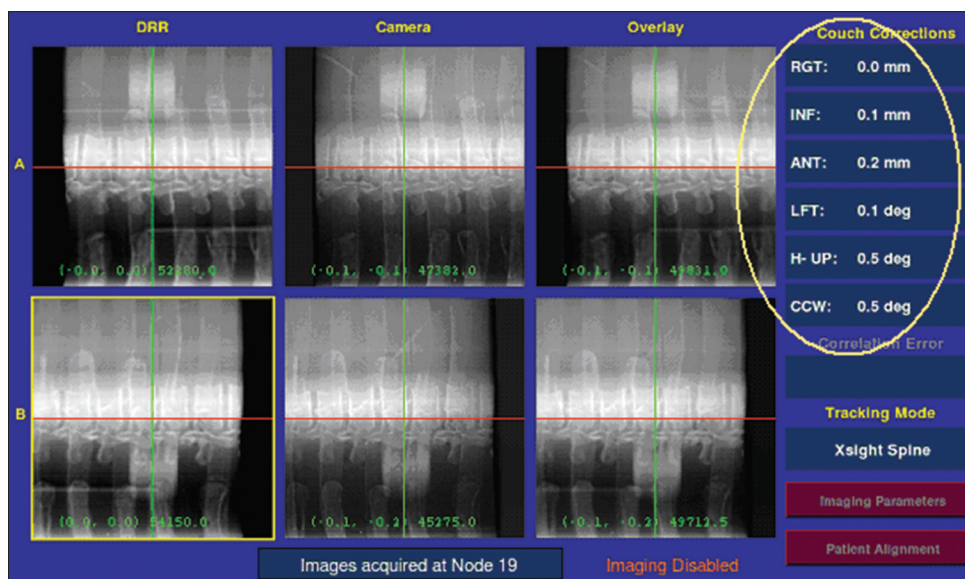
XSight Spine tracking registered the bony spine anatomy between the digitally reconstructed radiographs and the corresponding orthogonal stereoscopic images. The registration results, which are circled on the right, are three translational (left-right, superior-inferior and anterior-posterior) and three rotational errors (yaw, tilt, and roll). The shadow of the target appeared above (upper row) and beneath (bottom row) the spine structure
